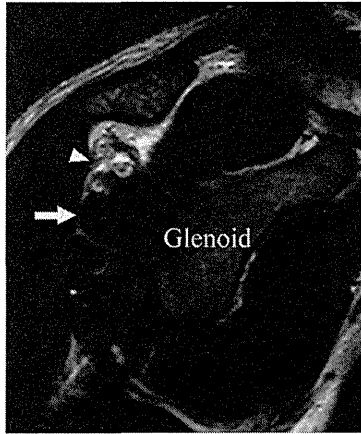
T2-weighted oblique sagittal MR image at the glenoid level (17 months after the injury). A cystic lesion appeared in the upper portion of the infraspinatus muscle belly at this level (arrowhead). On the other hand, the lower portion of the infraspinatus muscle remained intact (arrow)
